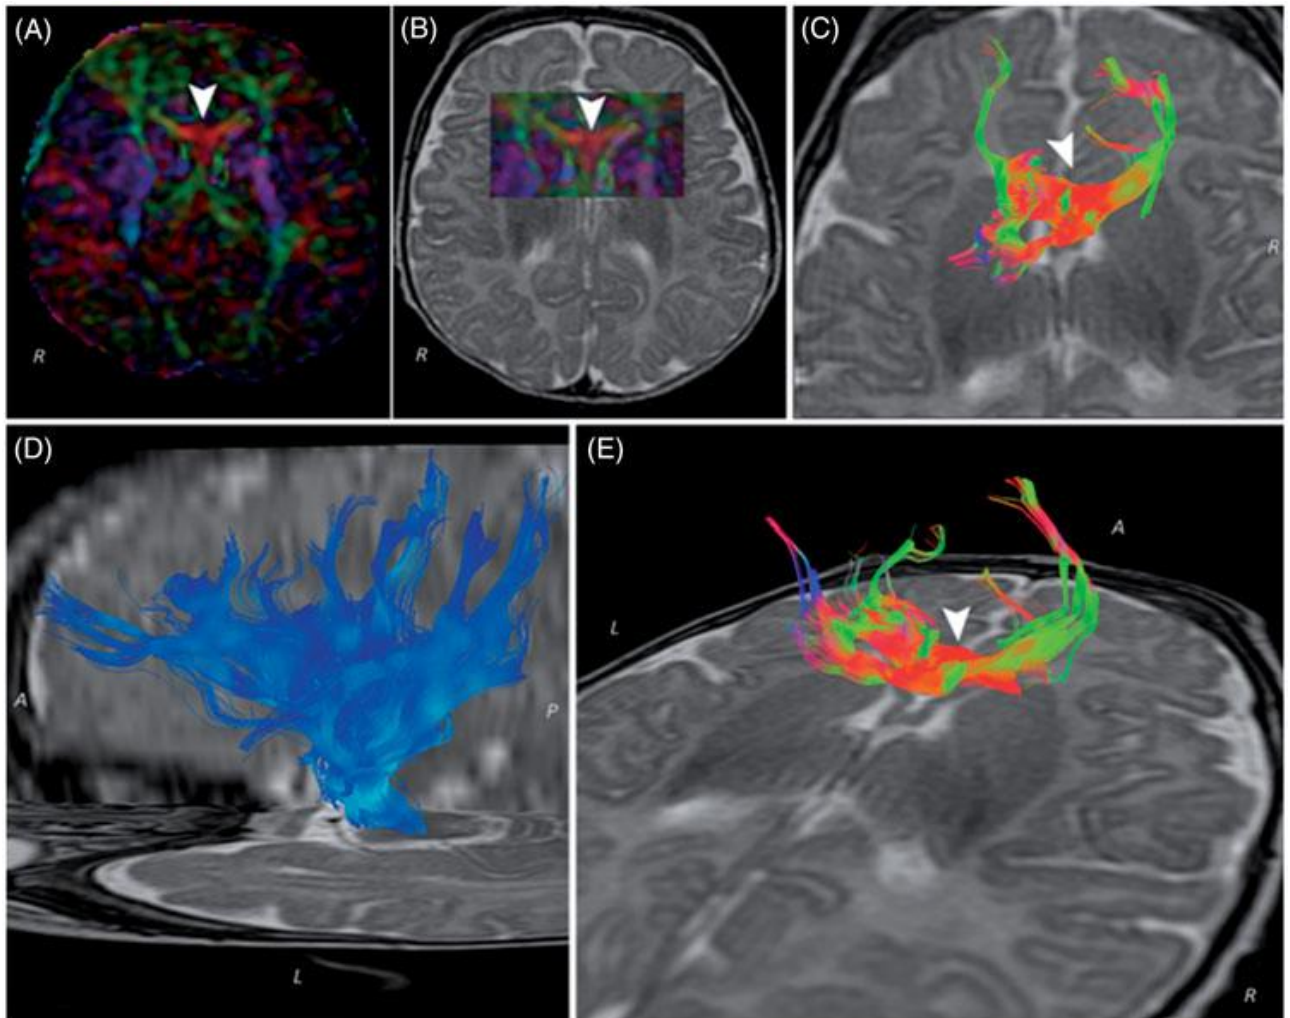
Diffusion Tensor Imaging (DTI) tractography performed at 3-months. A: Axial color coded Fractional Anisotropy (FA) map at the level of the anterior commissure (arrowhead). Please note that the anterior commissure, which in our case is enlarged (arrowhead), is conventionally red-colored since it is mainly composed of white matter fibers with a latero-lateral course at the midline level. B: Axial color coded Fractional Anisotropy (FA) map on top of an axial T2-weighted image at the level of the anterior commissure (arrowhead). C, D: Diffusion Tensor Imaging (DTI) fiber tractography of the enlarged anterior commissure on top of a T2-weighted image, respectively C) axial and D) oblique axial viewed from the top. The reconstruction of fiber tracts followed the FA color-coded convention. Please note that the enlarged anterior commissure is red-colored at the midline level (arrowhead). E: Diffusion Tensor Imaging (DTI) fiber tractography of left corticospinal tract does not reveal any gross morphological abnormality (right corticospinal tract not showed). Fiber tracts were arbitrarily blue-colored.
